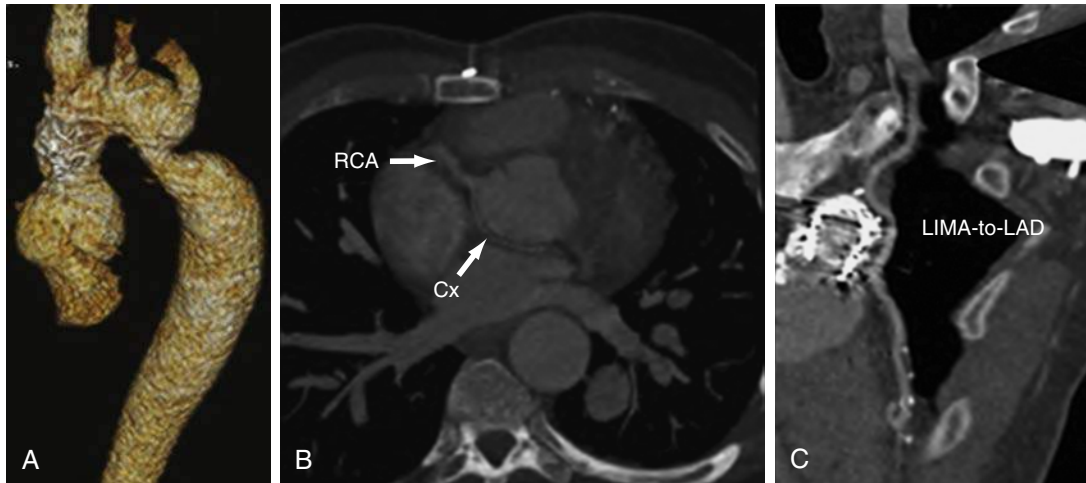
Follow-up CT scan reconstruction of a patient born with transposition of great arteries and A type interrupted aortic arch, who had previously undergone arterial switch operation and aortic arch repair with end-to-end anastomosis. A shows the anastomotic stenosis at the site of previous repair; B demonstrates circumflex and right coronary artery arising from the right anterior sinus; C shows the close relation between homograft in pulmonary position and left internal mammary artery graft to the left anterior descending coronary. Cx, Circumflex artery; LAD, left anterior descending coronary artery; LIMA, left internal mammary artery; RCA, right coronary artery.
